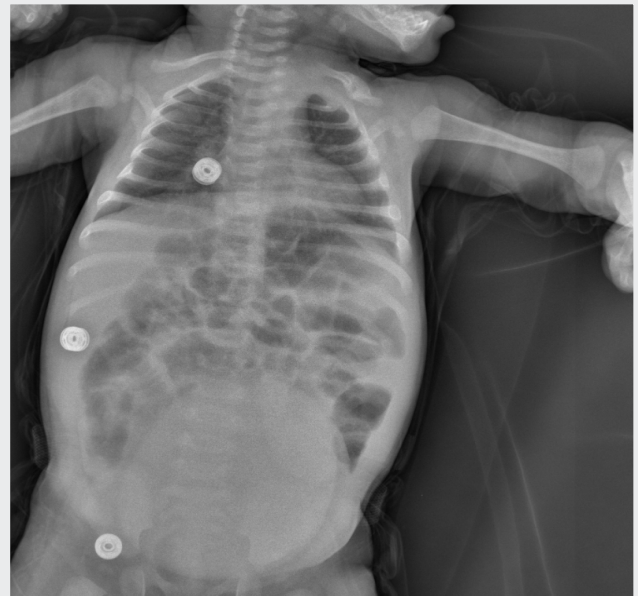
Patient's direct abdominal X-ray, demonstrating abdominal mass
